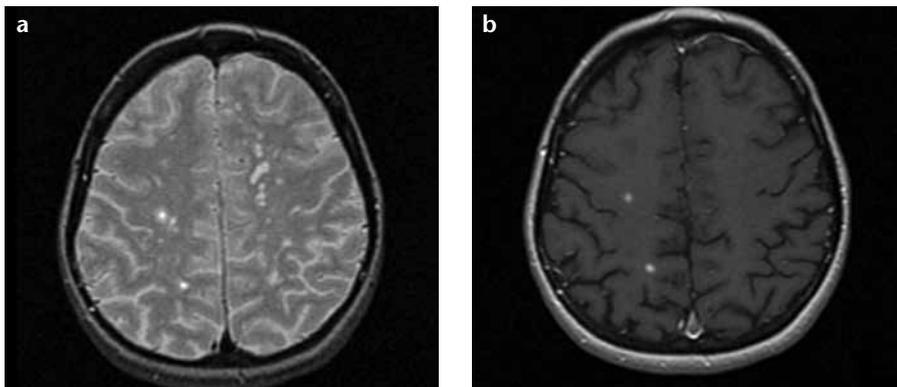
a, b. Two Type I lesions in the right corona radiata with their center homogeneously brighter than their periphery on T2-weighted images (a). Less hyperintense Type III white matter lesions are also present bilaterally. The corresponding contrast enhancement was nodular and visible only in Type I lesions (b).
